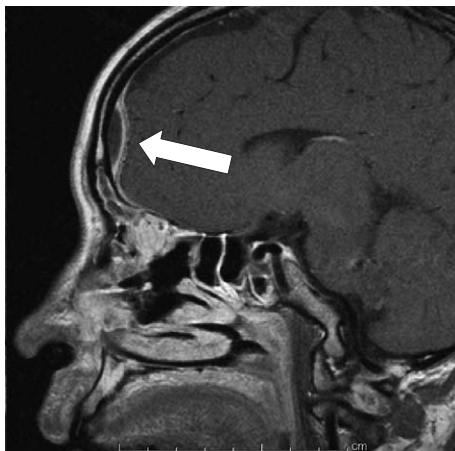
T1-weighted MR imaging with gadolinium enhancement obtained on April 8 showed a ringed low intensity area in the left frontal tip (white arrow).
